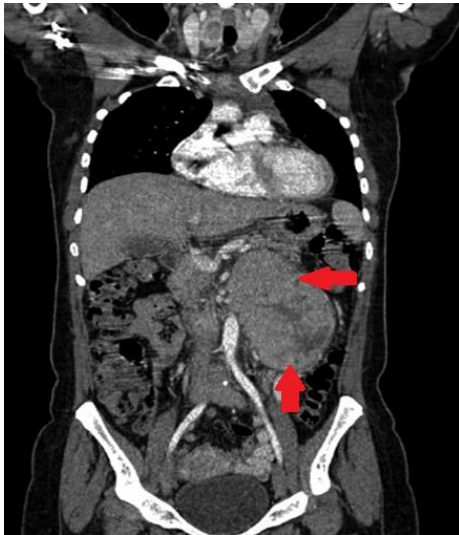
The coronal cuts of the computed tomography of the abdomen
